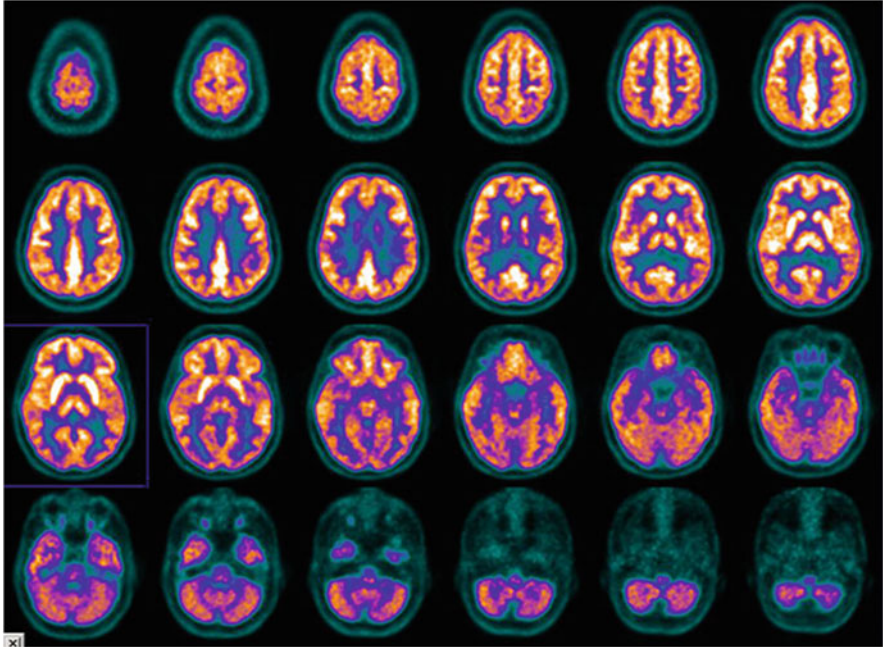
FDG-PET shows bilateral hypermetabolism in the frontal cortex, cingulate, and striatum
